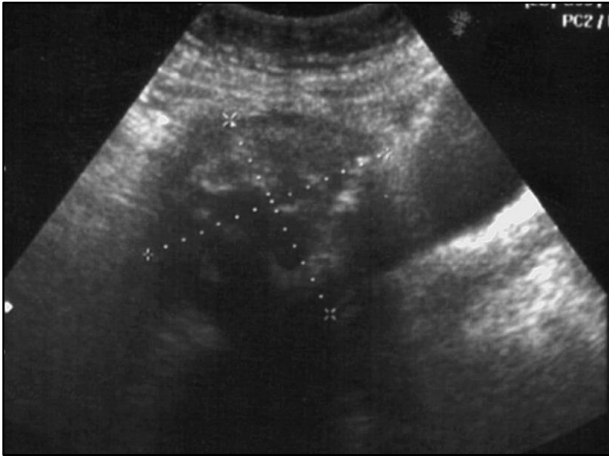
Ultrasound abdominal con presence de tumefaction y aparent trayecto fistulas.
